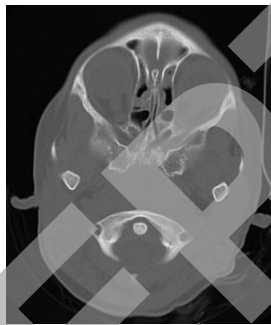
CT obtained 2 months postoperatively again demonstrates an intact C1 anterior arch.
